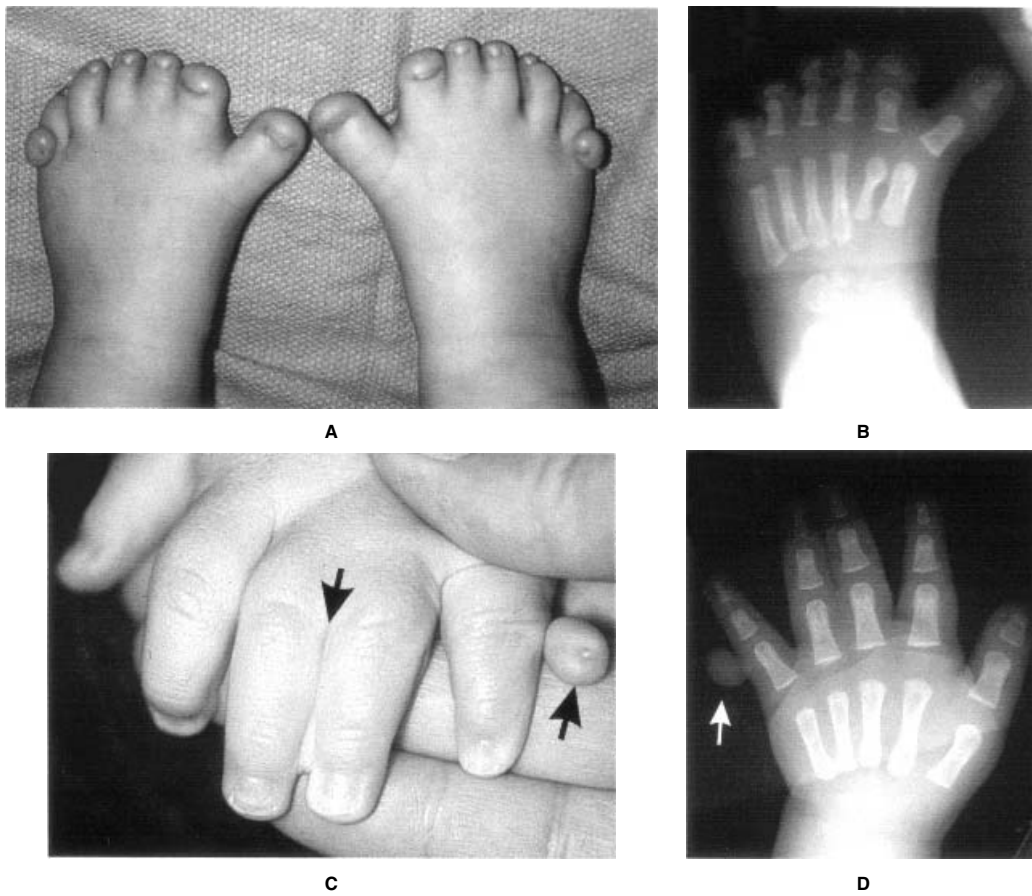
Greig cephalopolysyndactyly. Hands and feet of a female patient with Greig cephalopolysyndactyly syndrome aged 9 months. (A) Pre- and postaxial polydactyly of feet with cutaneous syndactyly of toes II to IV, and corresponding radiograph in (B) demonstrating complete duplication of first toe. (C) Postaxial polydactyly of hands (pedunculated postminimi, arrow) and cutaneous syndactyly of fingers III and IV (arrow). Corresponding radiograph is shown in (D). Note postaxial polydactyly without apparent ossification (arrow) and broad thumb.
